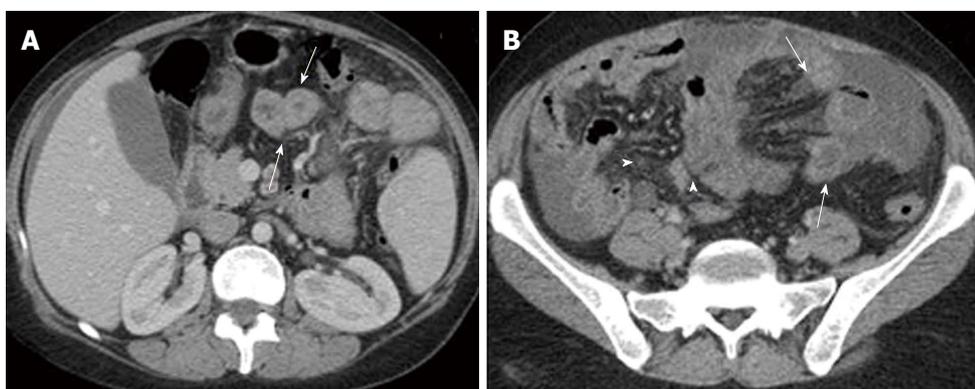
Triphasic post contrast axial computed tomography (portal phase) showing. A: Dilated small intestinal wall (arrows); B: Mesenteric hypodense bands indicating obstructed lymphatics (arrows), and dirty fat appearance due to mesenteric oedema (arrow heads).
